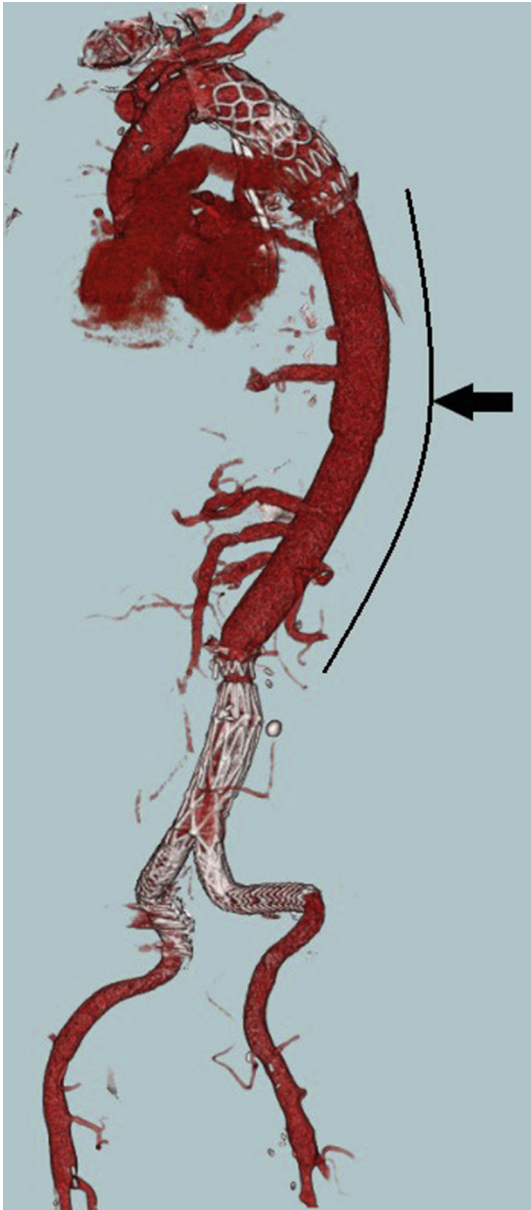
A three dimensional reconstructed image based on computed tomography after open surgery. The black line and arrow indicate the area in which the artificial blood vessel was replaced in this operation. The proximal portion was anastomosed to a Zenith TX-2 Dissection Endovascular Graft and the distal side was anastomosed to the level of the distal Zenith Dissection Endovascular Stent.
